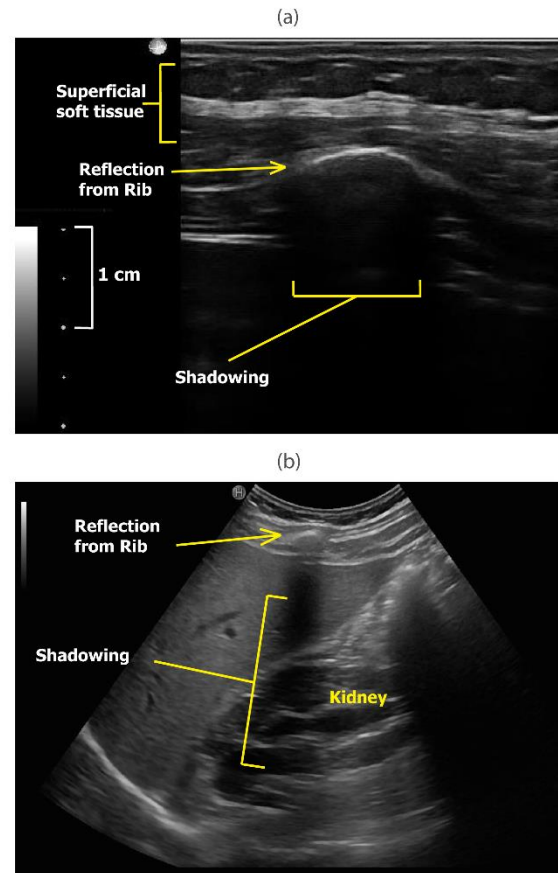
Anonymized ultrasound scans demonstrating the impact of ribs on ultrasound imaging. (a) An ultrasound image of a rib showing the clear reflection from the rib. (b) Ultrasound image of kidney showing the shadowing effect of a rib in the ultrasonic field.
